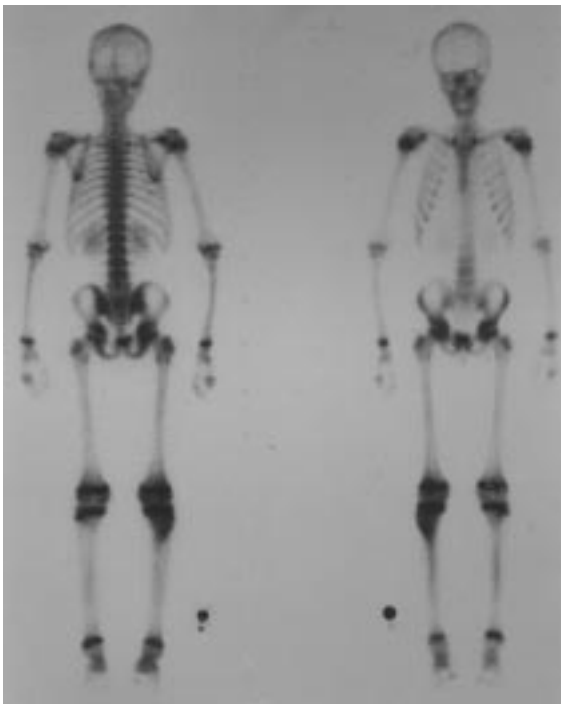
Whole-body Tc-99m bone scans of the patient whose plain radiograph is shown in Figure 6. The principal use of the bone scan is to screen the skeleton for other lesions. A secondary use is to evaluate a lesion suspected of being benign and inactive. If the lesion shows no increased uptake on the scan, it is reasonable to observe the lesion periodically.
